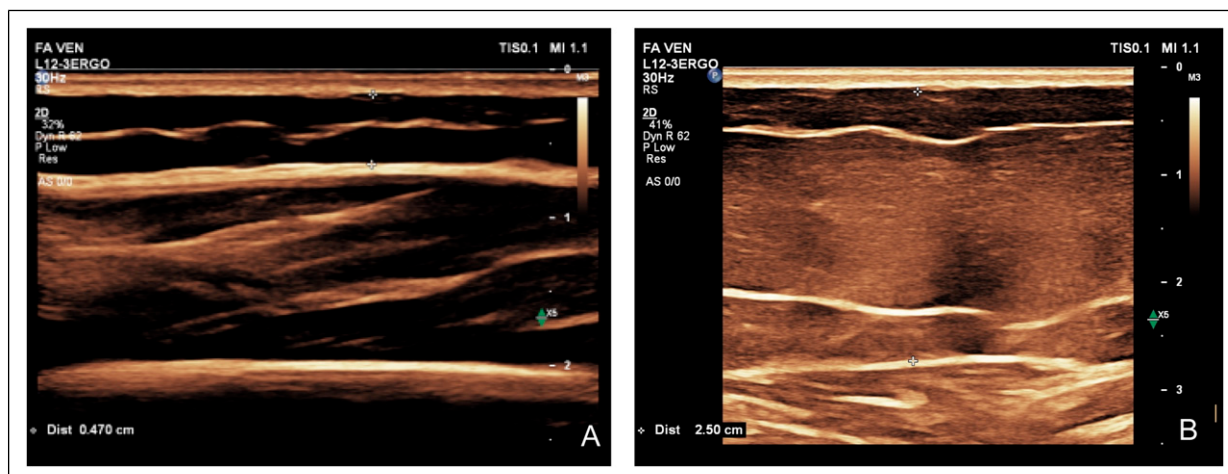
Subcutaneous thickness measurement technique: (a) B-mode ultrasound image demonstrates subcutaneous thickness measurement from the lower dermal border to the deep fascia (transition structure with musculature) in a control patient; (b) Subcutaneous tissue measurement in a patient with lipedema.
